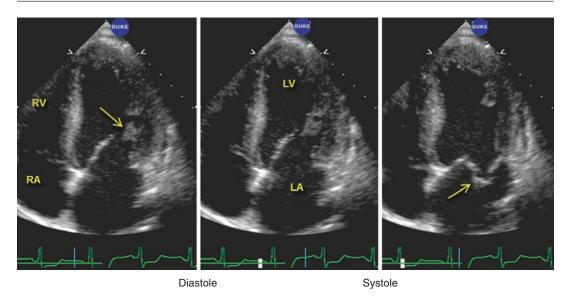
Sequential apical four-chamber views from a patient with a ruptured papillary muscle (arrows). The left and middle panels show the ruptured papillary head just
